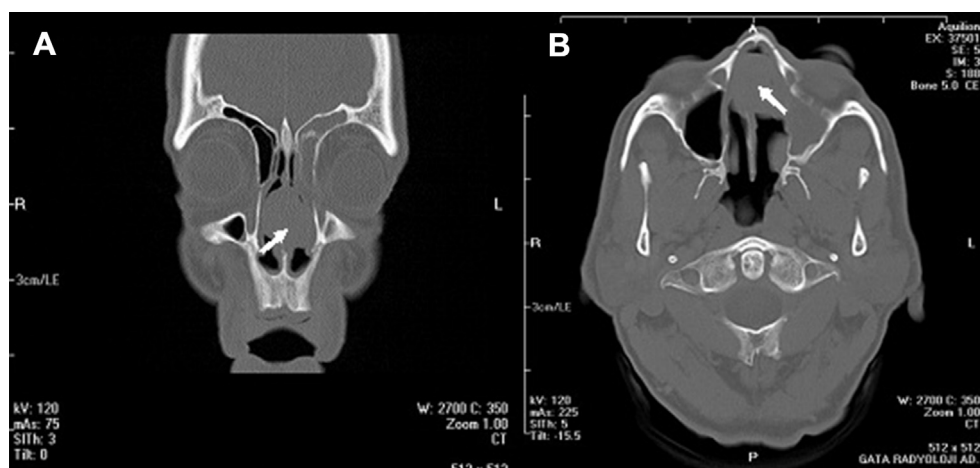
Computed tomography sections, (A) coronal and (B) axial, demonstrating a mass lesion consistent with a neoplastic growth completely filling the left nasal passage, perforating the septum, and even extending to the right nasal passage (arrows).
